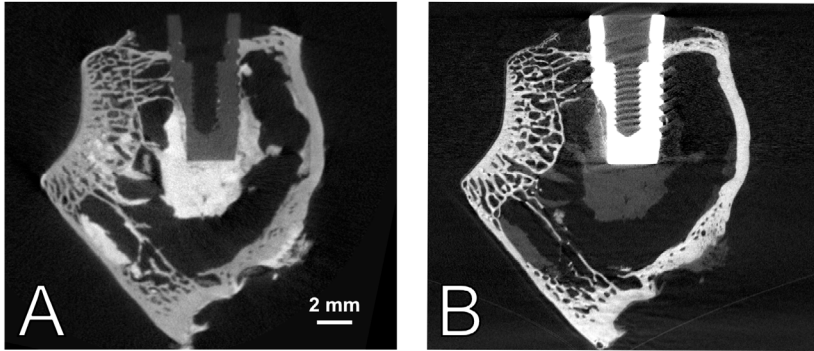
Complementarity of x-ray and neutron imaging.
